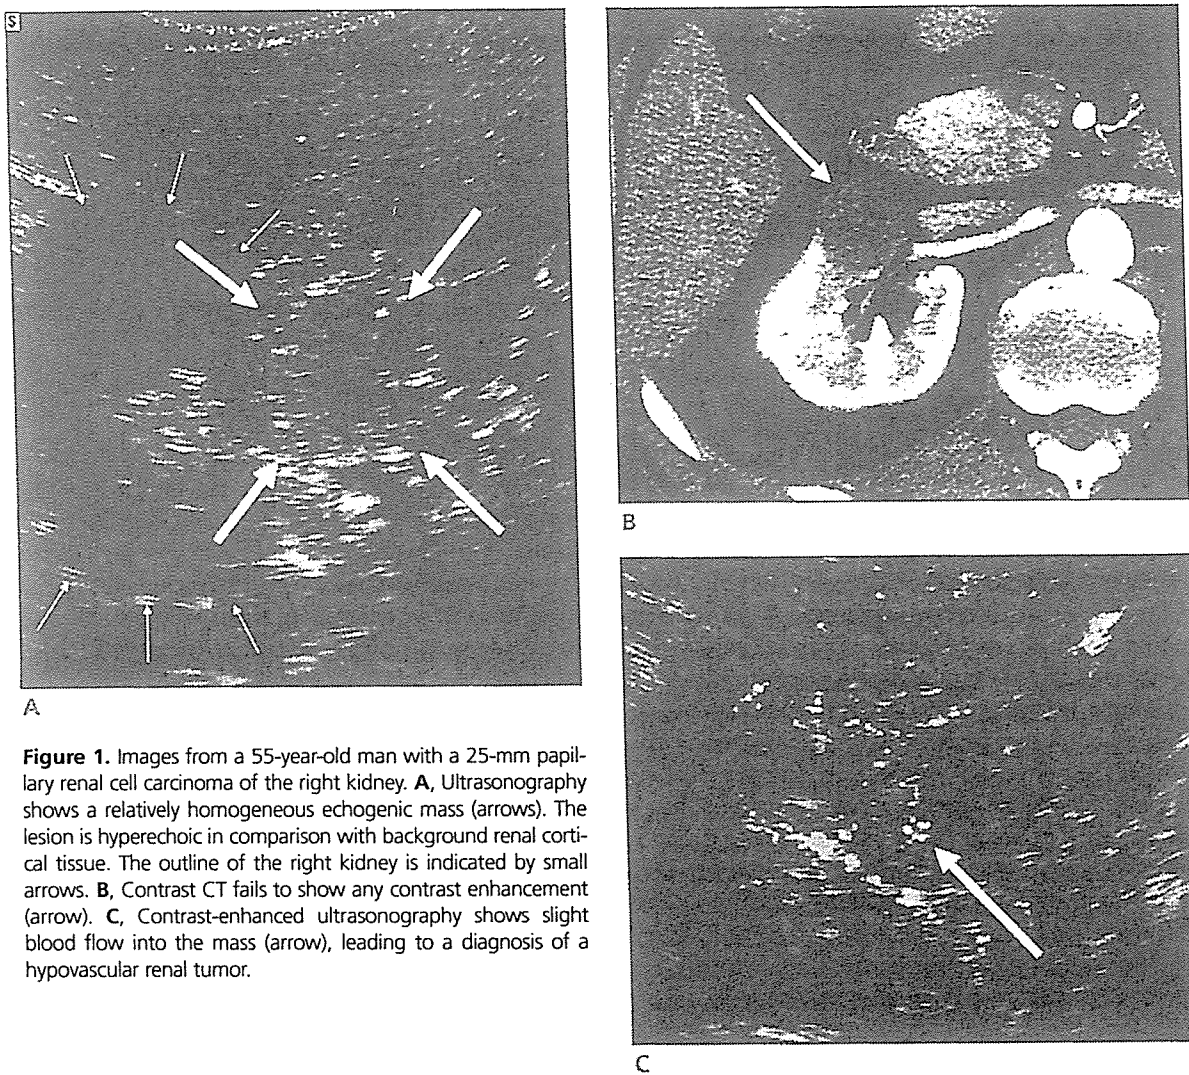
Images from a 55-year-old man with a 25-mm papillary renal cell carcinoma of the right kidney. A, Ultrasonography shows a relatively homogeneous echogenic mass (arrows). The lesion is hyperechoic in comparison with background renal cortical tissue. The outline of the right kidney is indicated by small arrows. B, Contrast CT fails to show any contrast enhancement (arrow). C, Contrast-enhanced ultrasonography shows slight blood flow into the mass (arrow), leading to a diagnosis of a hypovascular renal tumor.
